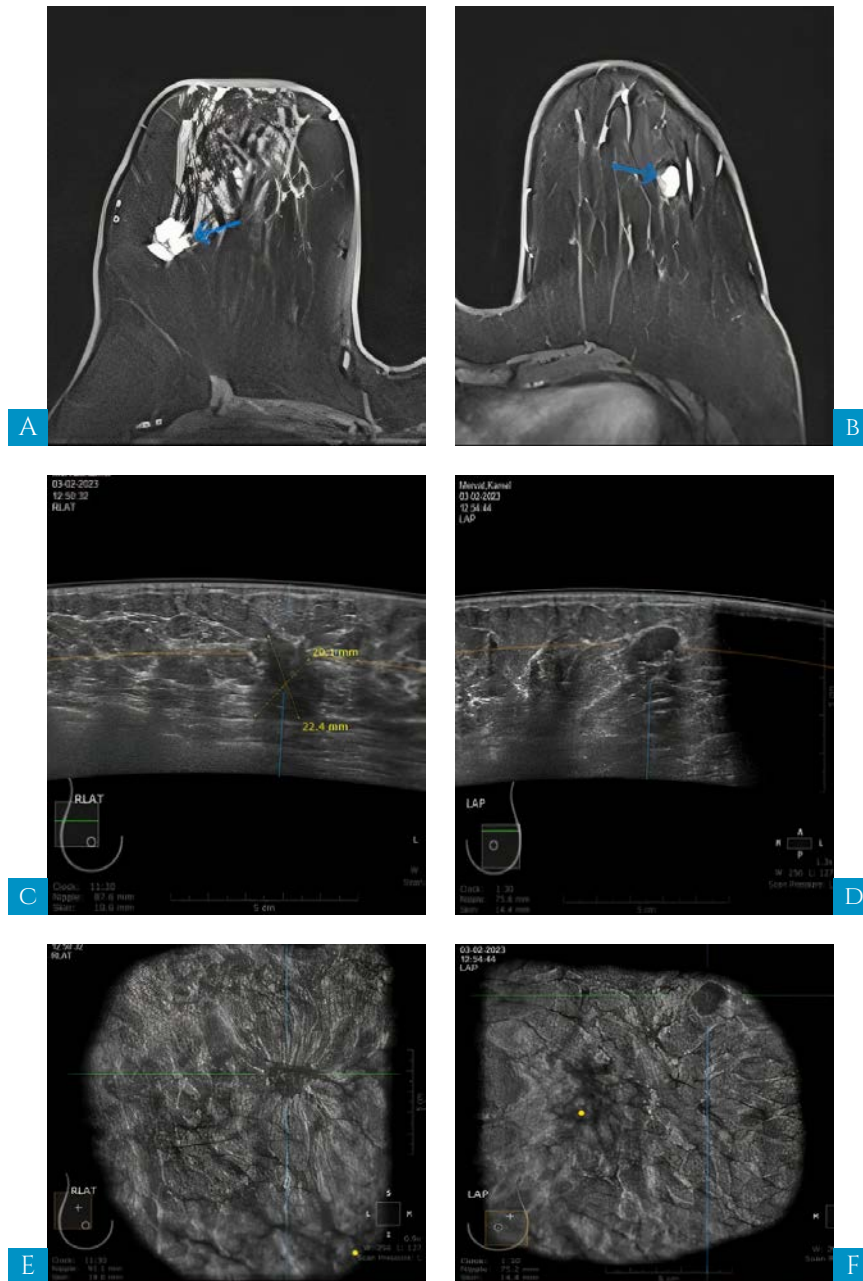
A 61-year-old female patient presenting to us by a clinically palpable right breast lump by doing ABUS and MRI left breast lesion is detected A & B: MRI post contrast with fat sat image axial view of both breast show: A. Right UOQ speculated mass lesion with anterior ductal extension reaching to the nipple (BIRAD V). B. Left oval shaped lesion with circumscribed margin BIRAD III. C. right lateral view axial image show irregular shape mass lesion with speculated margin (BIRAD V). D. left anteroposterior axial image show mass lesion of indistinct margin and non-parallel orientation (BIRAD IV). E. left anteroposterior coronal image show a defect with micro lobulated margin (BIRAD IV). F. Right coronal view shows a defect with retraction phenomena (BIRAD V).
